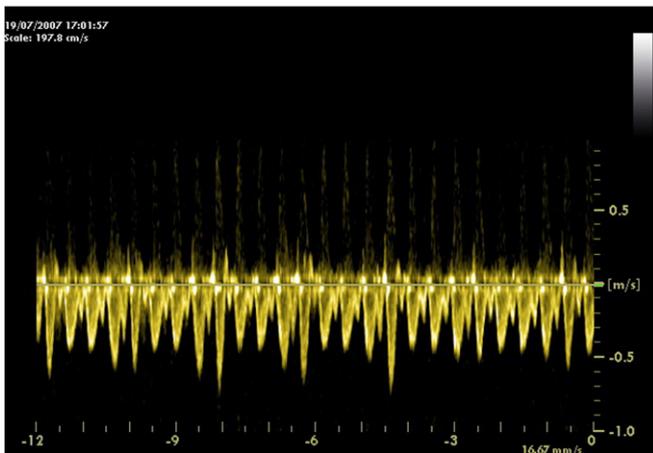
Doppler recording of blood velocities in the superior vena cava during foetal breathing movements at 36.1 weeks of gestation.
